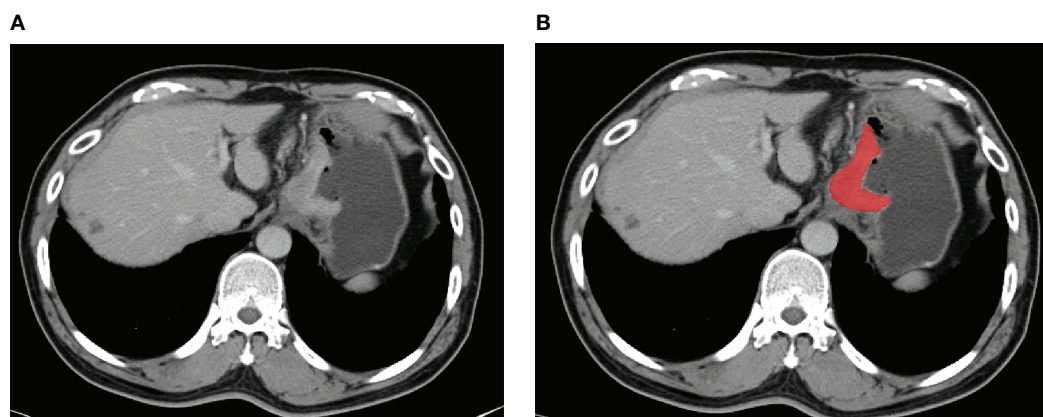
An example of manual segmentation in gastric cancer. (A) Localized thick wall of gastric cancer with enhancement is observed on the portal venous phase computed tomography (CT) image. (B) Manual segmentation on the same axial slice is depicted with red label.
